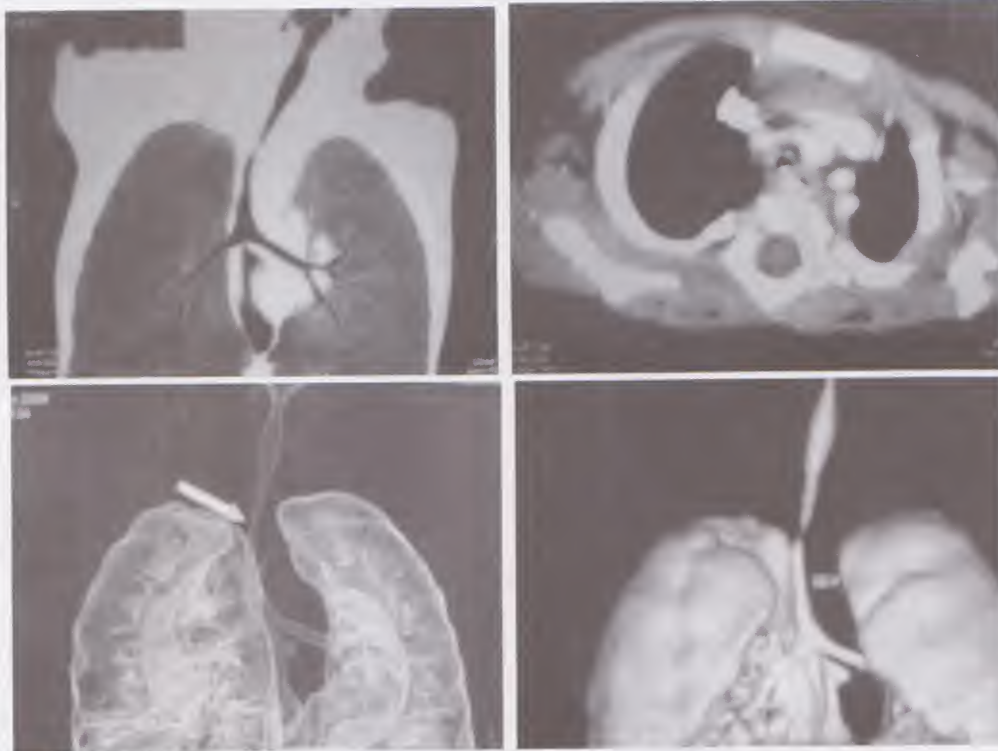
CT scan images showing tracheal stenosis; coronal (upper left), transverse (upper right) and 3-D reconstruction image (lower images)
